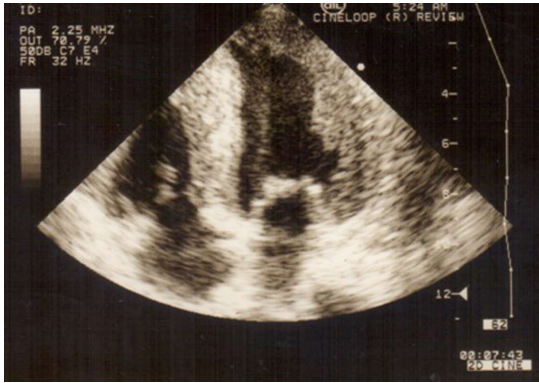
Patient with secondary cardiac amyloidosis due to familial Mediterranean fever. Echocardiogram shows hypertrophic amyloid infiltration and increased hyperechogenic “granular sparkling” myocardium with increased myocardial wall thickness.
